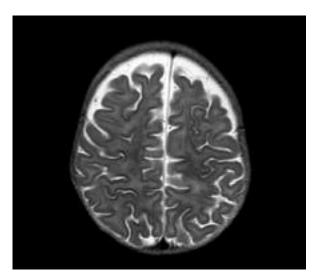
SE/T2 weighted MR images – lack of myelination pattern in white matter of frontal lobes, thin cerebral cortex.
